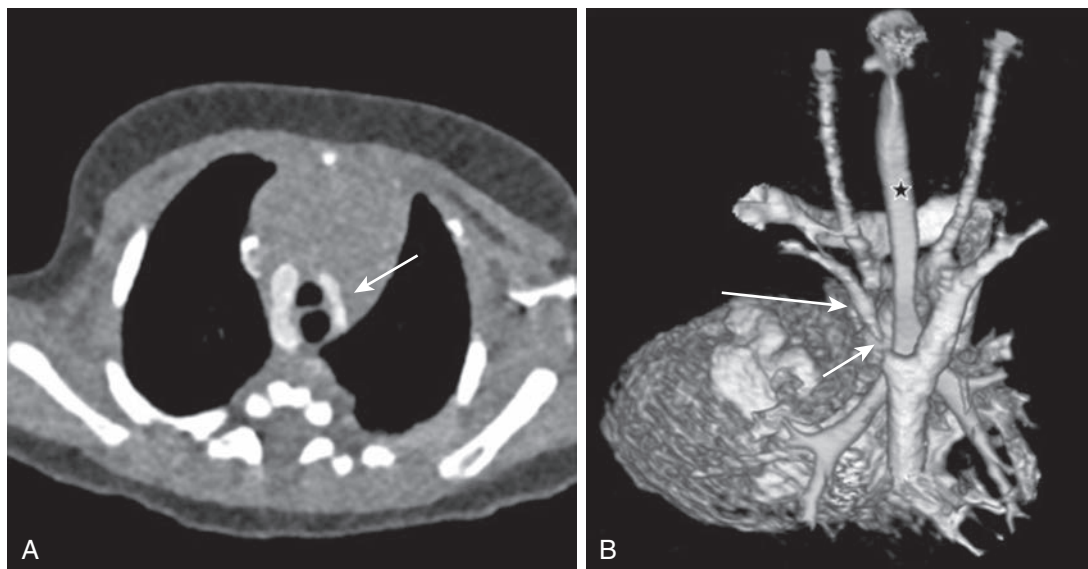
Axial (A) and volume-rendered three-dimensional (B) images of a computed tomography angiogram of the chest demonstrate a double aortic arch with hypoplastic left arch (*long arrow, A and B*) with atresia of the posterior aspect of the left arch (*short arrow, B*). The volume-rendered image (viewed from behind) better demonstrates the spatial relationships of the arches to each other as well as to the encircled trachea (*star*).
